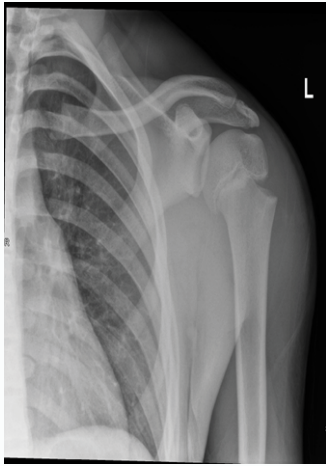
AP view x-ray of left shoulder.
